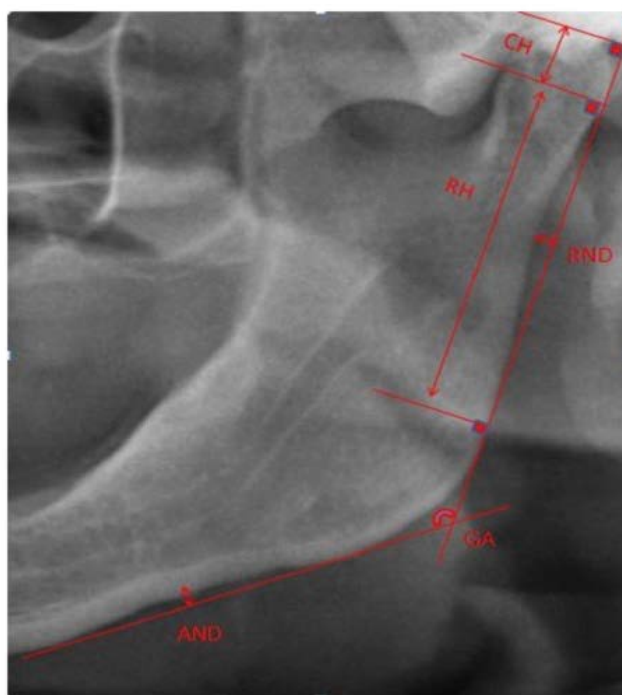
Mandibular landmarks used for measuring the gonial angle, ramus height, condylar height, antegonial notch depth and ramal notch depth on panoramic radiograph
